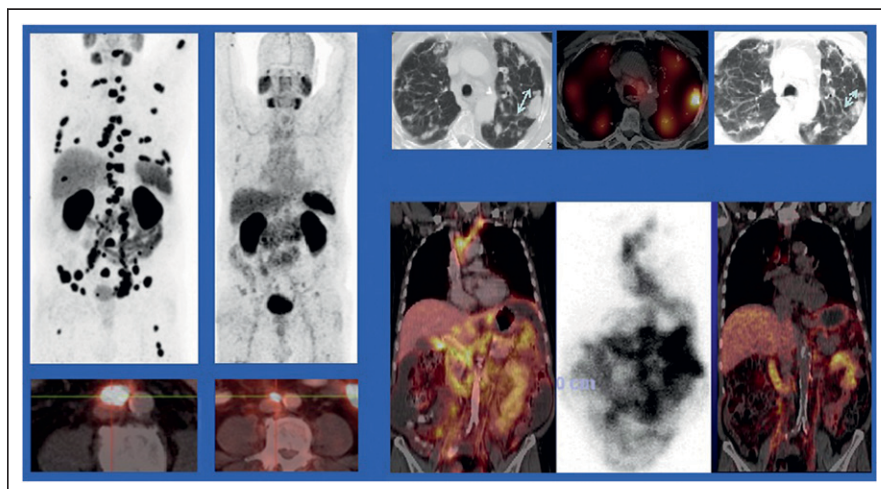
$^{11}\text{C}$ -acetate PET/CT in newly diagnosed myeloma. Left block: Patient in whom L3-measured generalized marrow activity (GMA) was 5.6 for  $^{11}\text{C}$ -acetate (left) and 2.7 for  $^{18}\text{F}$ -FDG PET (right) and who survived for 27 mo. Right block: Patient in whom L3-measured GMA was 3.6 for  $^{11}\text{C}$ -acetate (left) and 2.7 for  $^{18}\text{F}$ -FDG PET (right) and who survived for more than 4 y.
